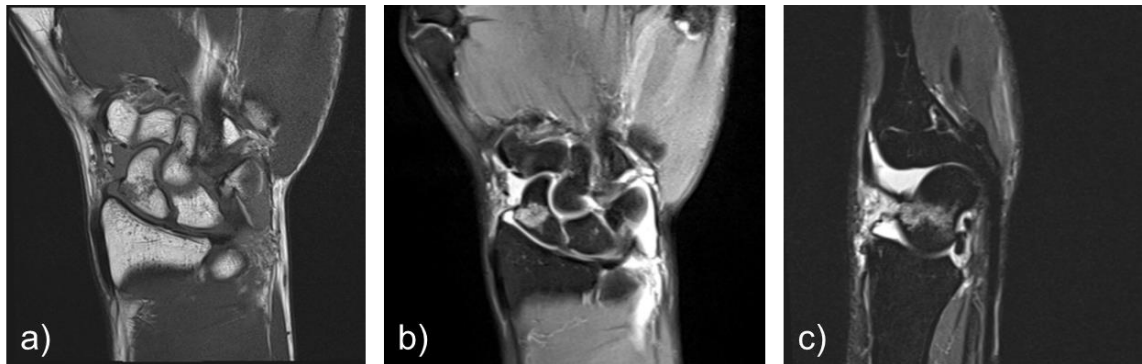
Imaging of patient with fracture of the scaphoid waist showing the abbreviated MRI: (a) coronal T1; (b) coronal PDFS; and (c) sagittal STIR views.
